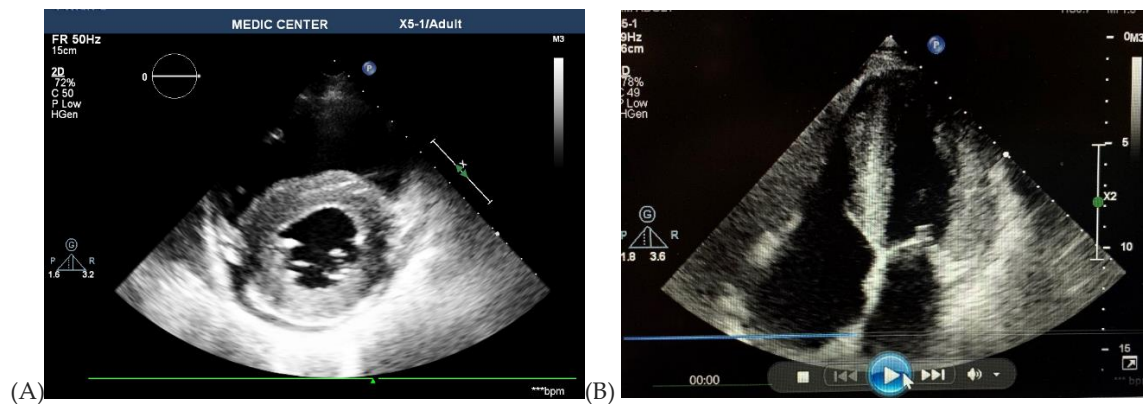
A: Parasternal SAX view showed the same image of ground glass appearance and the small pericardial effusion. B: Apical 4 C views showed biatrial enlargement, thickening of IAS and LVH with myocardial infiltration.
